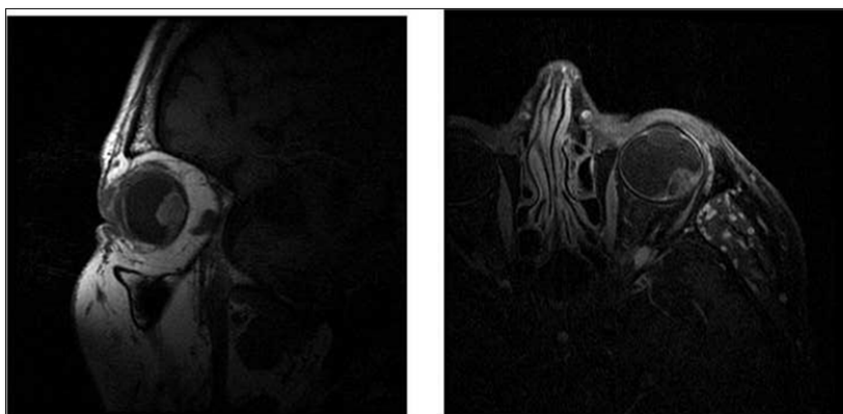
Magnetic resonance images (A) axial and (B) sagittal T1 weighted image with gadolinium showing anteroposterior (height of the tumor).
